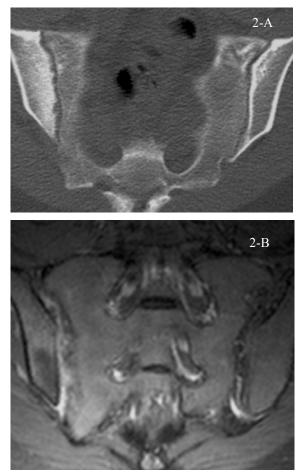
Images of a 26-year-old HLA B27 positive man with 6 months ILBP associated psoriatic skin. a) Coronal CT scan demonstrates sclerosis, cortical irregularity and erosions of right iliac surface. b) Corresponding SE PC T1 weighted shows obvious contrast enhancement in the ligamentous joint space. Assessment of the left sacroiliac joint by the CT and MR is normal.
